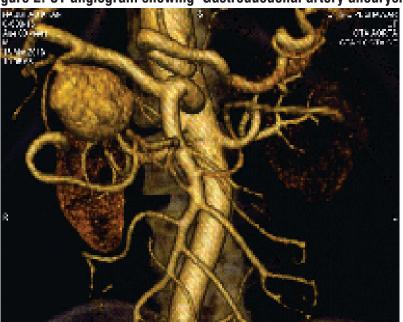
CT angiogram showing Gastroduodenal artery aneurysm
